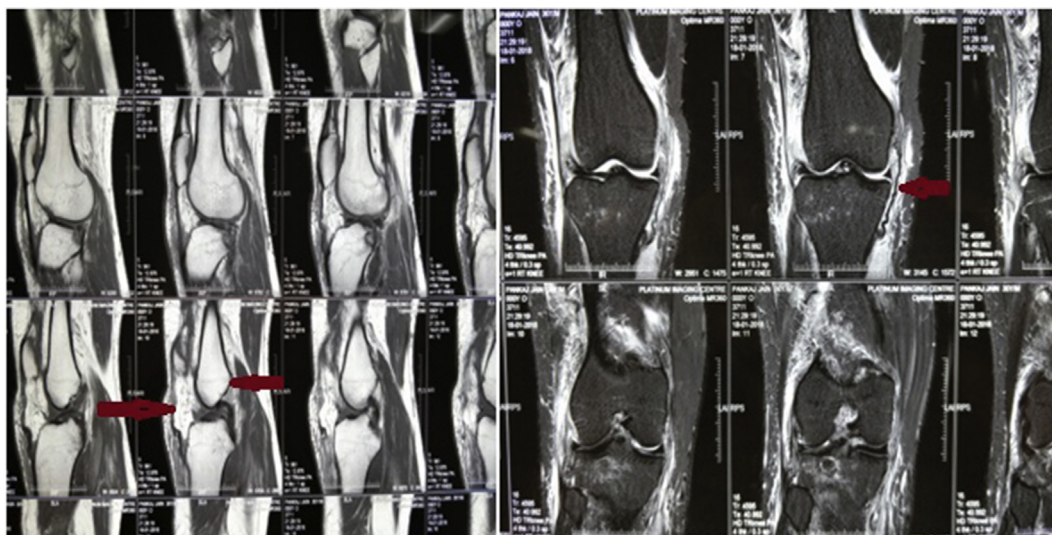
MRI (Sagittal & Coronal) images of patient 2, Arrows showing Anterior cruciate ligament fibre discontinuity, Patellar Tendon tear & Medial collateral ligament avulsion from femur side with tortuosity due to laxity/tear of ligament.
